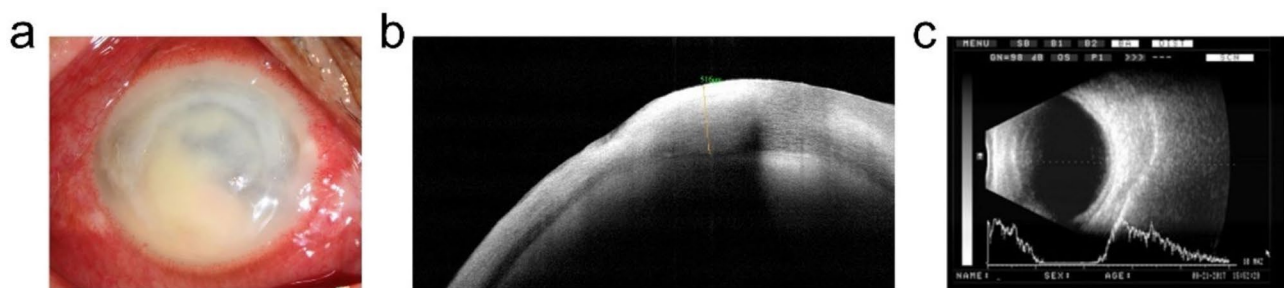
Inclusion criteria for patients. Slit-lamp image of corneoscleral infection (a); AS-OCT demonstrated involvement of the total cornea, with the yellow line indicating a corneal thickness of 516 μm (b); B-scan ultrasound showed no signs of pre-operative endophthalmitis (c)
